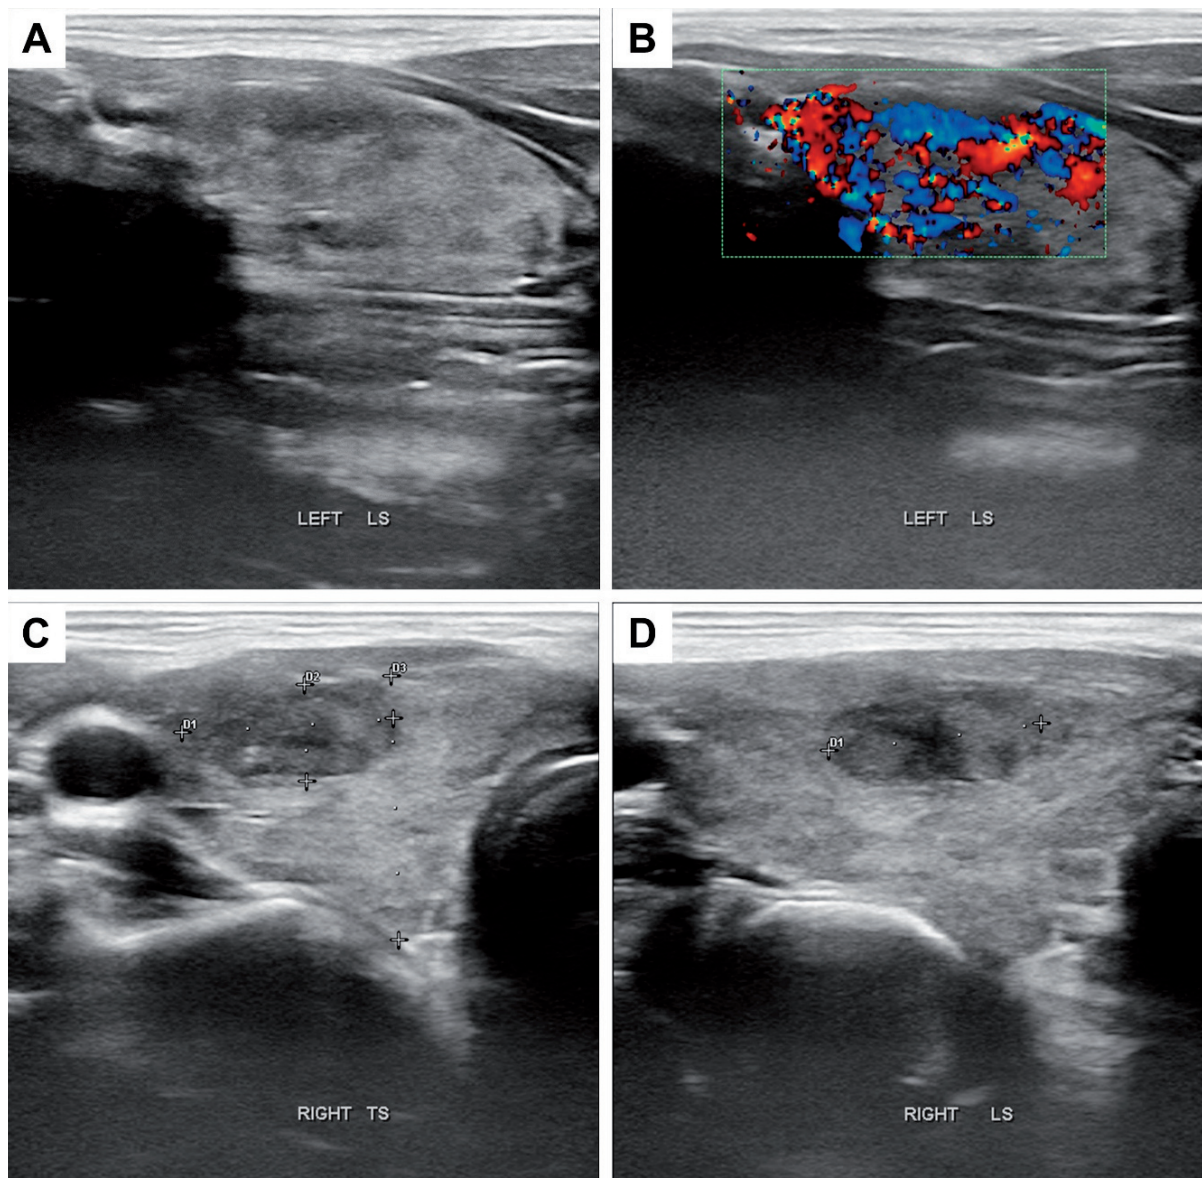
Bedside thyroid ultrasound scan showing an enlarged thyroid with diffuse and marked heterogeneity (A), along with an intensely increased vascularity on power Doppler, indicative of 'thyroid inferno' (B). A thyroid nodule was also visible on the right lobe (C); this measured 16.1x7.3x16.3mm and was hypoechoic with irregular borders, subcapsular and in contact, but not clearly infiltrating, the anterior capsule (D) and stratified as a 'high risk' nodule
